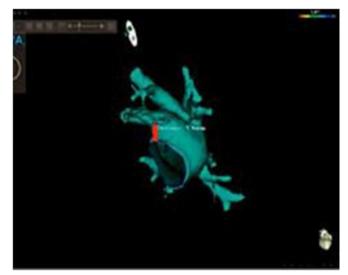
Computed tomography of the heart. integrated with the Carto 3 system. Distance between LAA and mitral annulus. (adapted from reference [10]).
